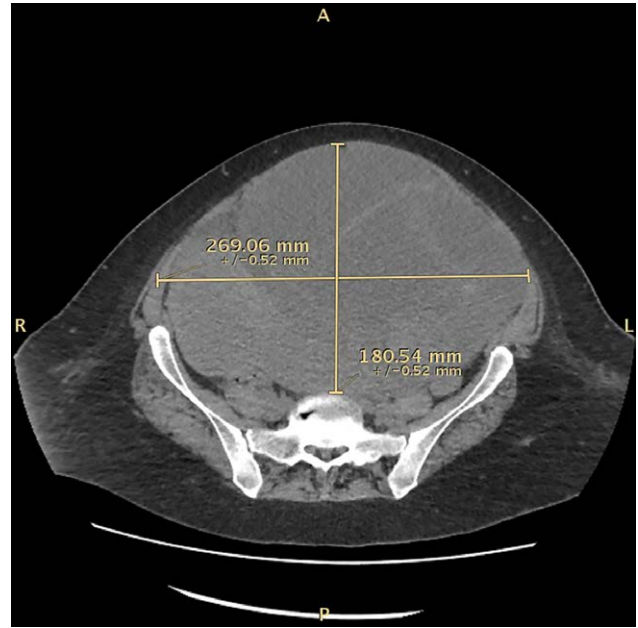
CT scan showing a 26.9 × 18 cm abdominal and pelvic mass.
